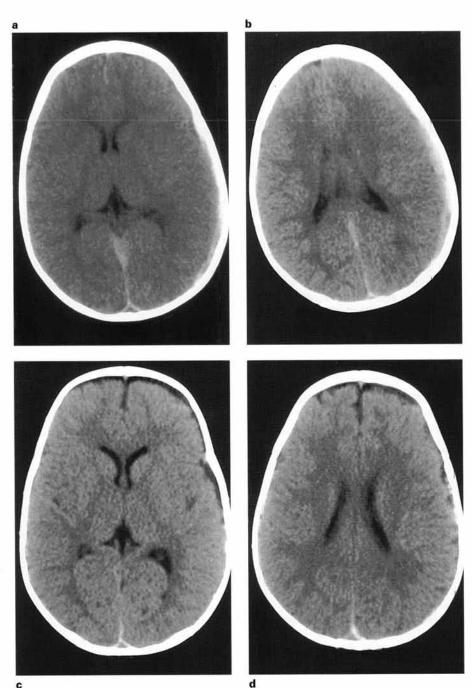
CT scans case 2. a, b Acute unenhanced study, showing a heterogeneous collection of blood overlying the convexity of the left cerebral hemisphere and extending in a subdural location along the interhemispheric fissure. c, d 24 h later, subdural blood still outlines the posterior sagittal sinus but with almost complete clearing of the high attenuation in the superficial CSF spaces.
